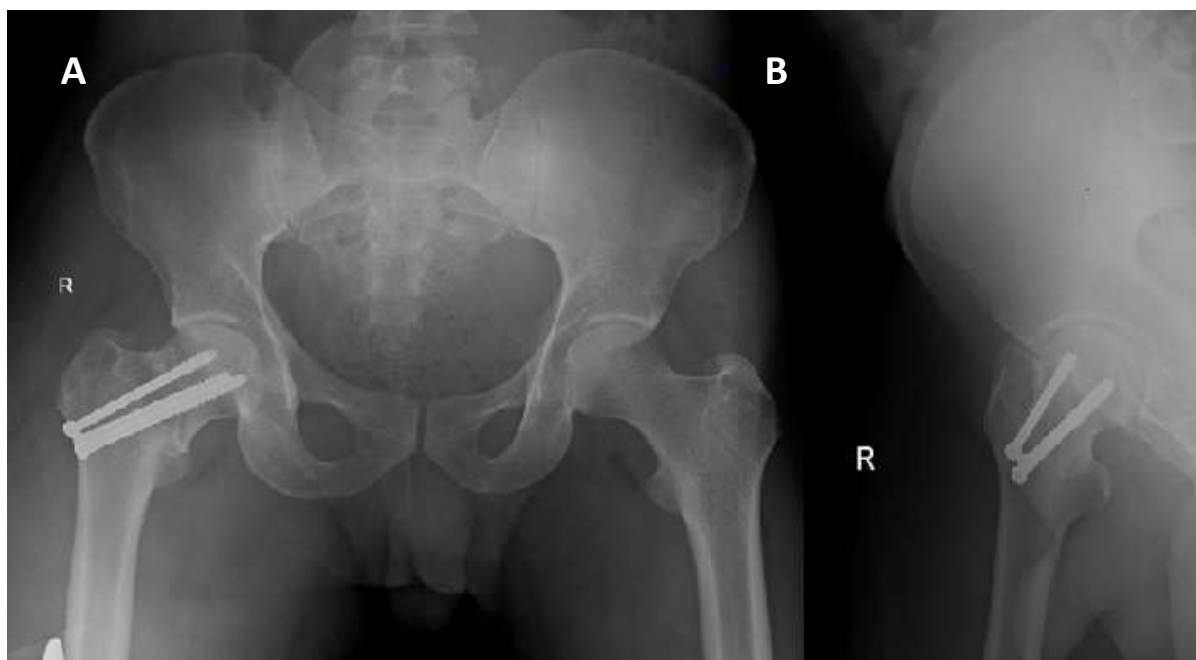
Post-operative radiograph of pelvis with both hips with neck femur fracture right side fixed with cannulated screws; A: Antero-posterior view; B: Lateral view
